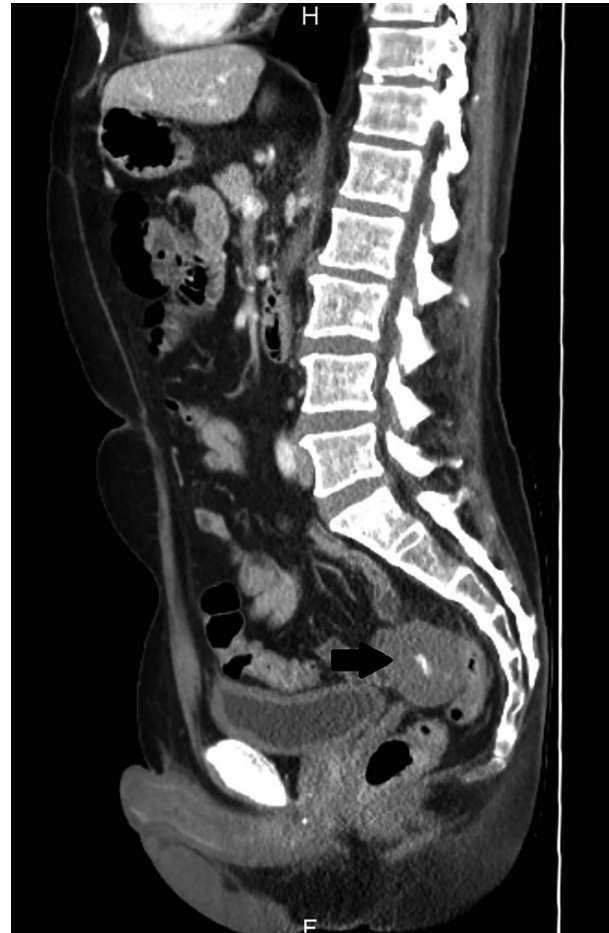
Computed tomography scan showing a well-described nodular structure of 6 cm with a central dense core of 0.5cm, localized next to the rectosigmoid.
